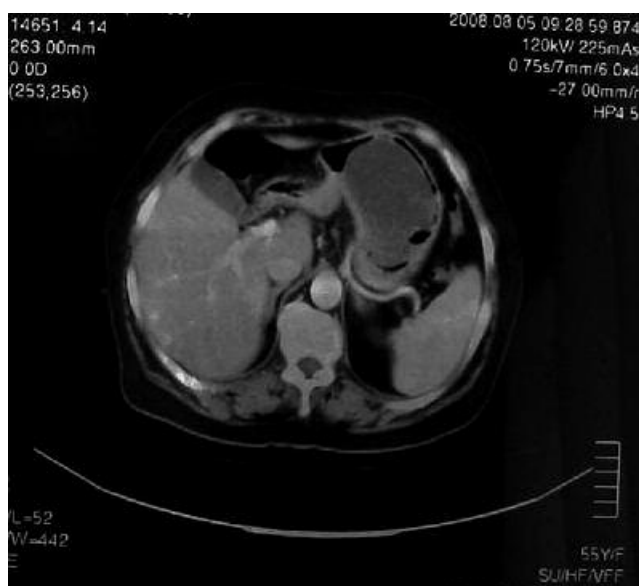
Abdominal computed tomography showing a large mass located in the gastric wall.
